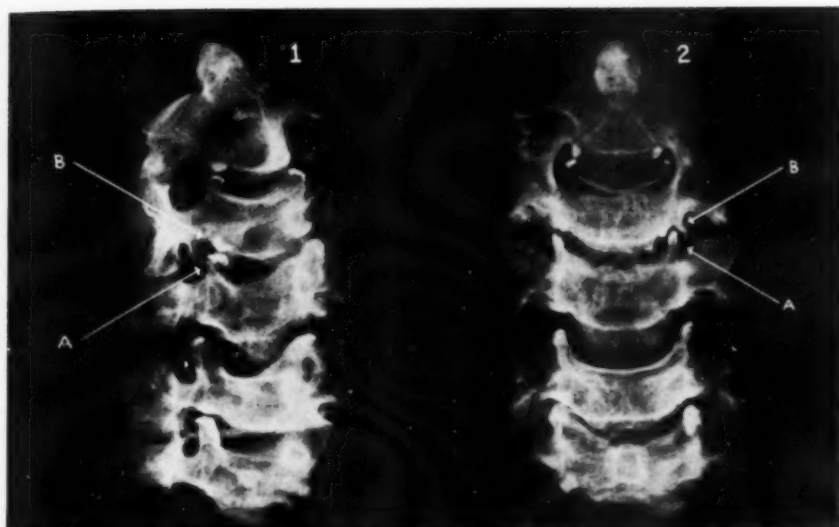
Roentgenogram of vertebral bodies from the same skeleton as Fig. 2, demonstrating the male (A) and female (B) parts of Luschka joints in the anteroposterior (2) and oblique (1) projections. Both male and female parts of the joints of Luschka have been painted with an opaque medium.
